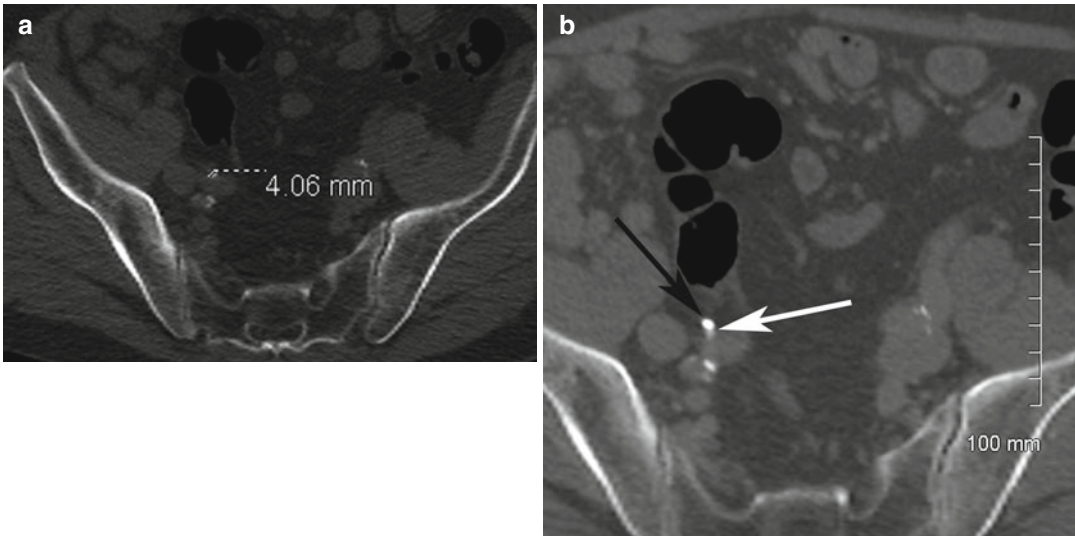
(a) Axial NECT performed for right flank pain. The calcified structure was initially misinterpreted as a calculus in this thin patient with mild atherosclerotic changes. There was no proximal hydronephrosis. (b) The patient underwent CT urography a few weeks later for
